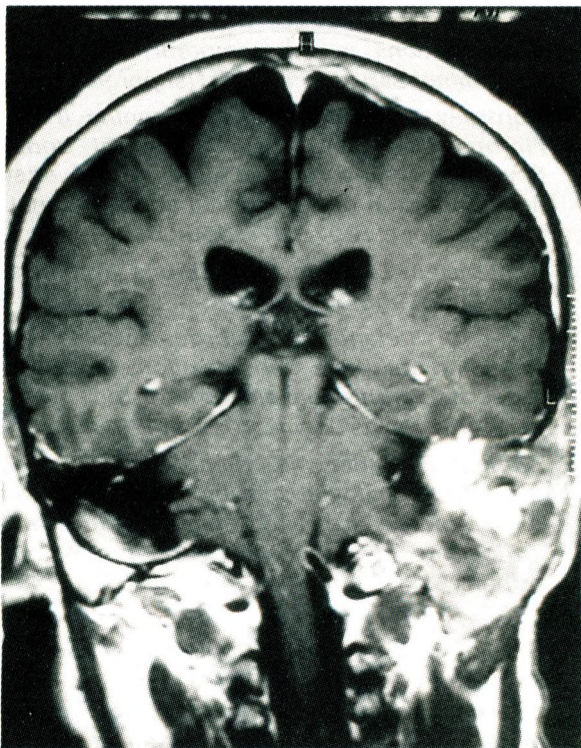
MRI of the presented case.
